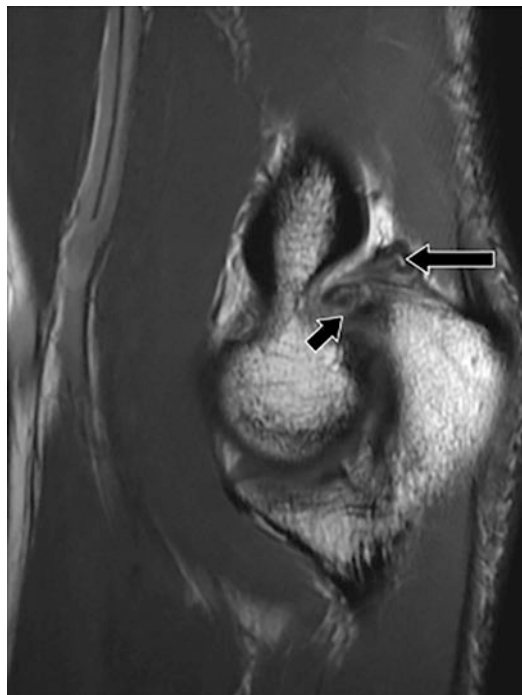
Sagittal FSE MR image shows additional findings of posteromedial impingement with marked synovial scarring at the posteromedial aspect of the elbow joint surrounding a loose body (*long arrow*). The *short arrow* indicates a chronic fracture through an olecranon osteophyte
